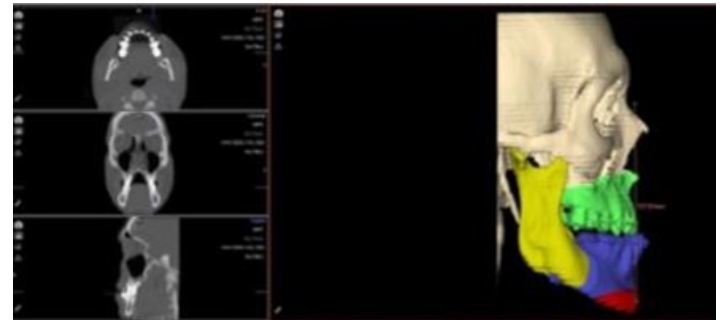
Import CT to DICOM format to Nemo studio, in addition the intraoral occlusal scanner in STL files.
